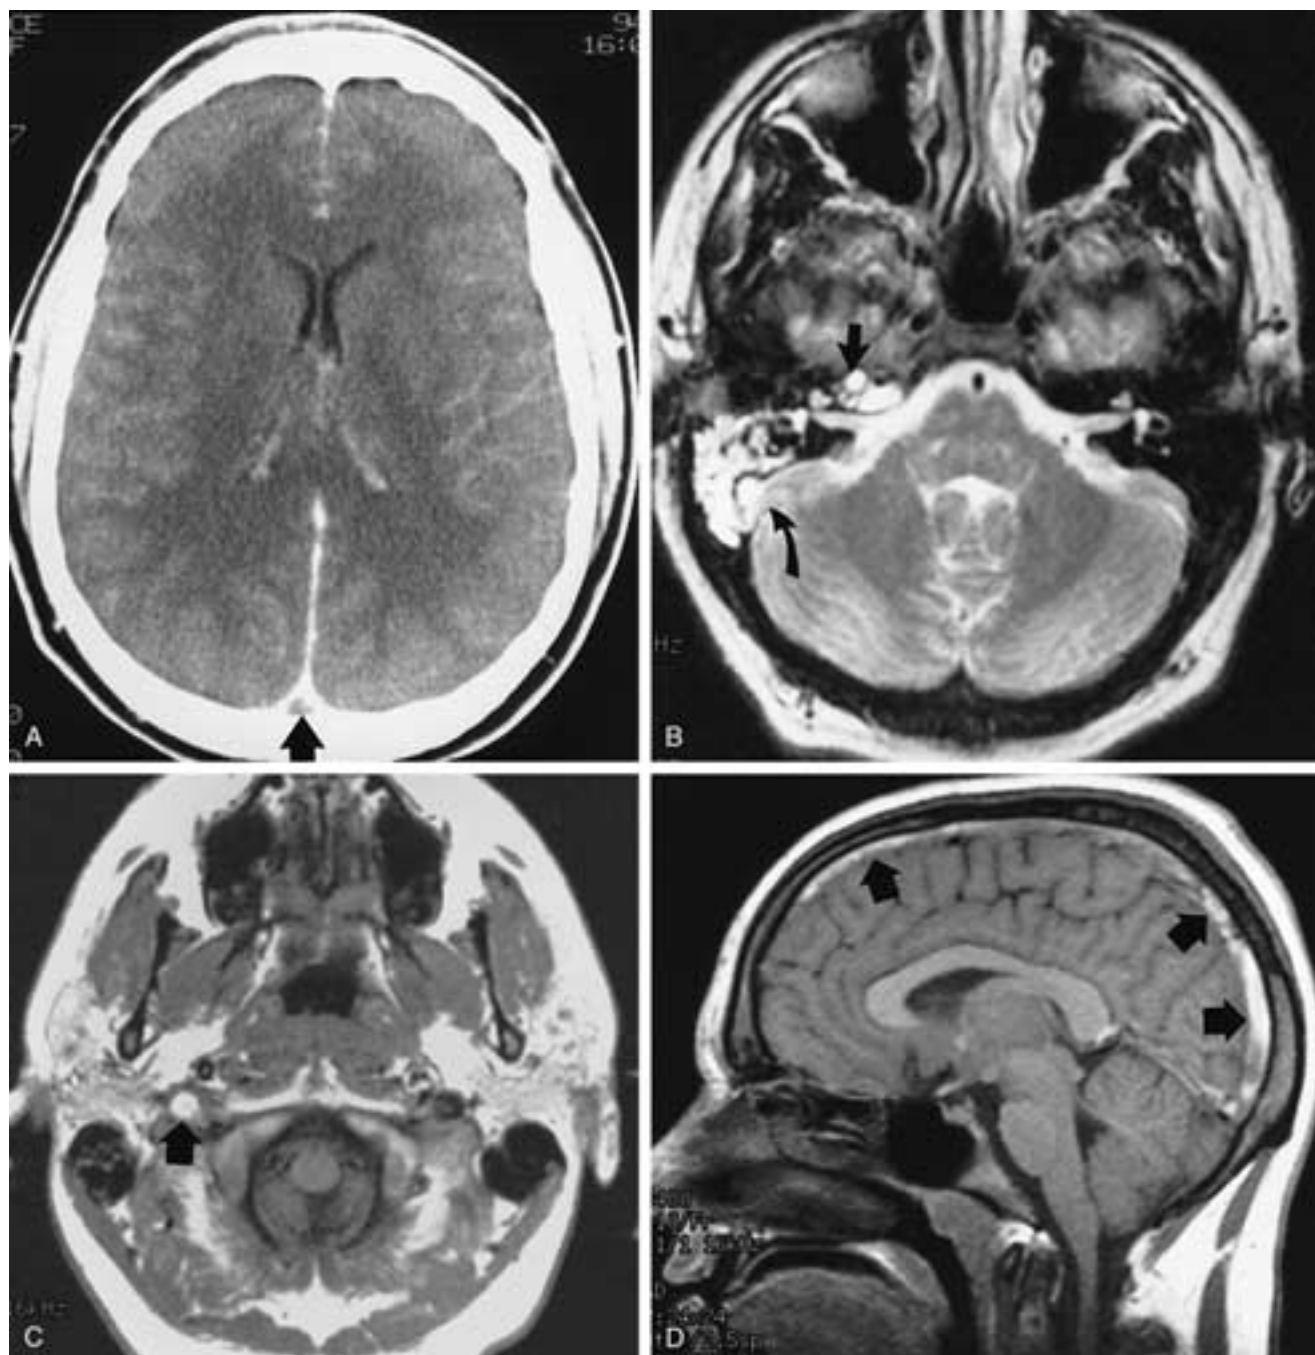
Mastoiditis with venous sinus thrombosis and venous infarction. This is a 19-year-old man who presented with headache and transient left-sided weakness. A, Contrast-enhanced CT image shows clot in the superior sagittal sinus (*arrow*) (“empty delta sign”). B, T2-weighted image shows hyperintense fluid in the mastoid and the petrous apex (*arrow*). Note the abnormal high signal caused by thrombus in the right sigmoid sinus (*curved arrow*). C, T1-weighted image. The normal flow void in the jugular vein has been replaced by the bright signal of methemoglobin in the thrombosed jugular vein (*arrow*). D, T1-weighted midline sagittal MR image shows hyperintense thrombus in the superior sagittal sinus (*arrows*).
